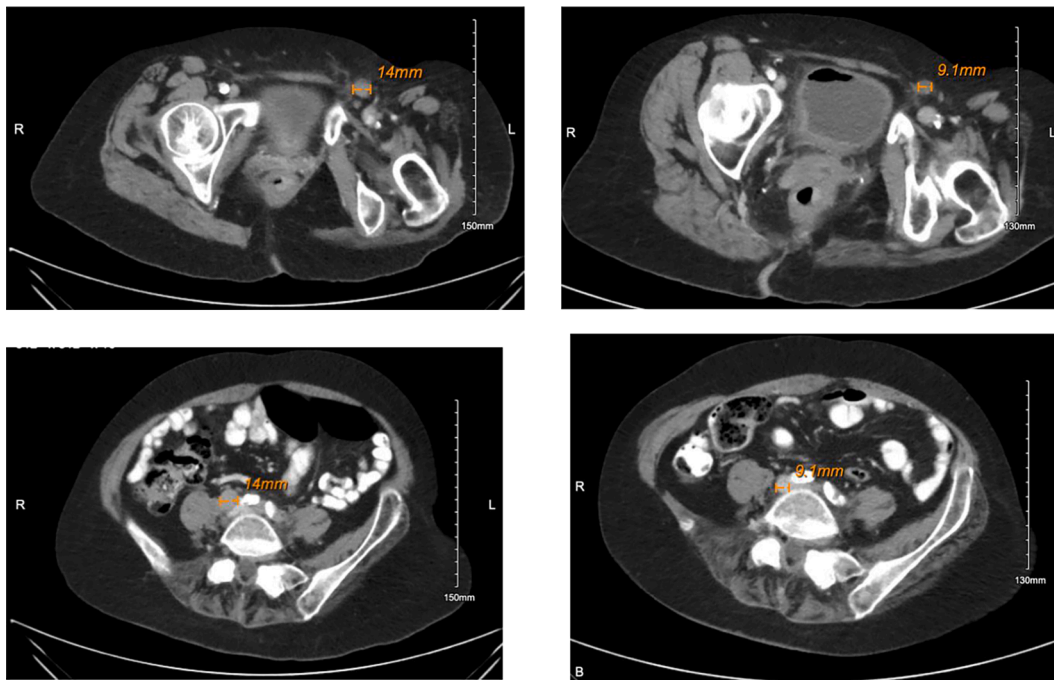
Treatment response. Left upper panel: left inguinal lymph node on baseline CT scan. Right upper panel: partial response in left inguinal lymph node status post cycle 4 docetaxel. Left lower panel: right common iliac lymph node on baseline CT scan. Right lower panel: partial response in right common iliac lymph node status post cycle 4 docetaxel.
